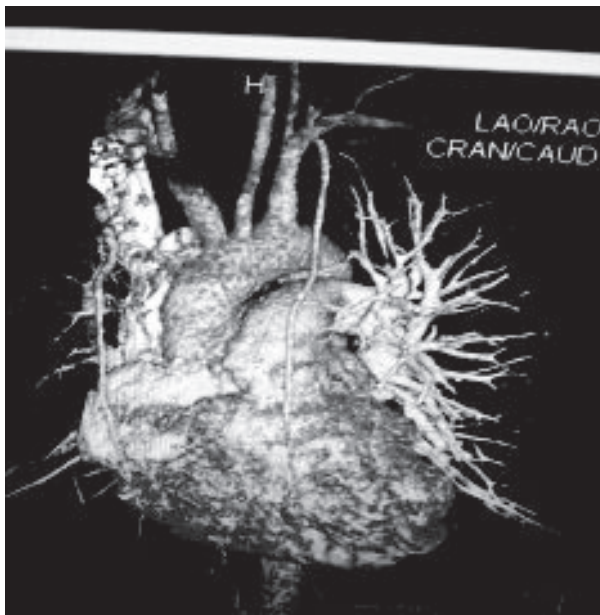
CT pulmonary Angiogram showing filling defect is seen in the right hilum with evidence of complete occlusion of RPA & partial occlusion of MPA.
